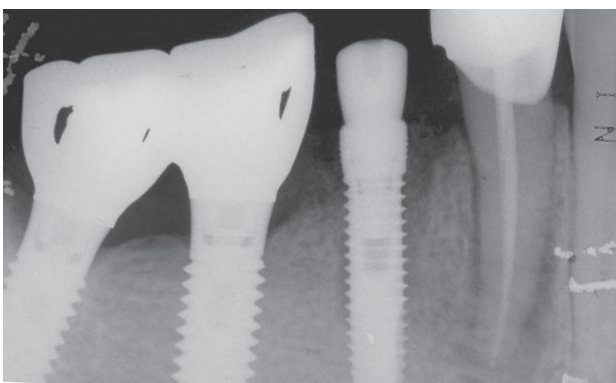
Radiograph taken one month after treatment.
